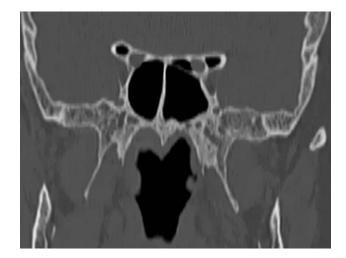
Coronal CT head scan of male patient (52 year-old). It is percepted transversal septum in projection of left optic canal as well as pneumatization of anterior clinoid processes
